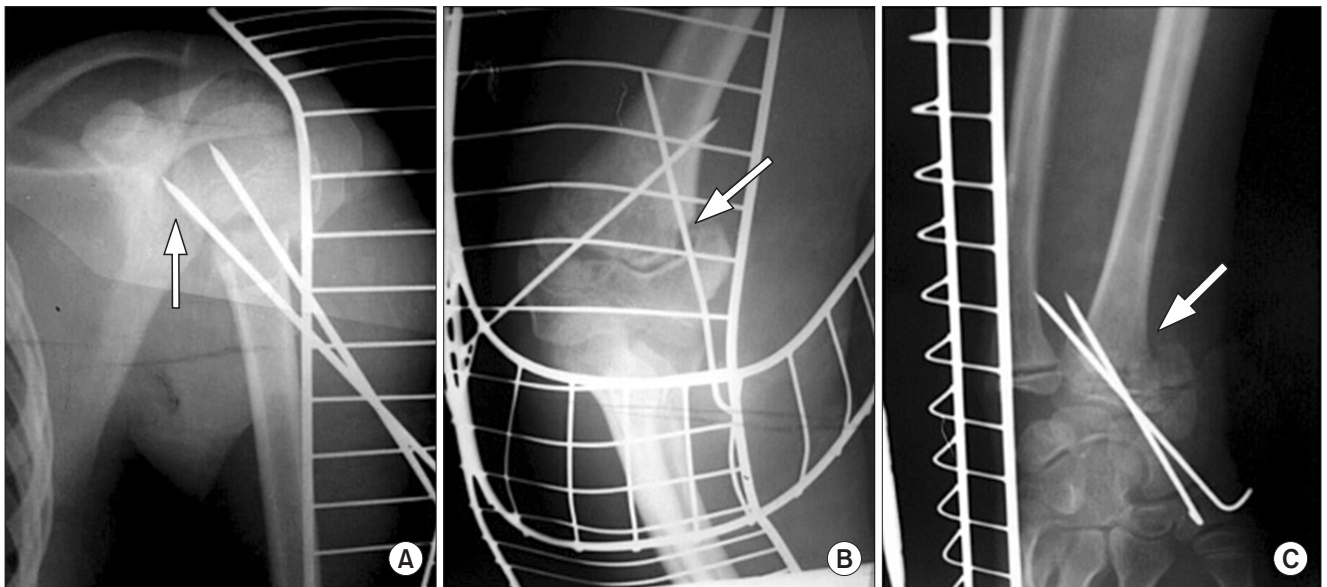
X-rays showing reunion of the limb at 6 weeks after surgery in the ipsilateral humeral (A), supracondylar (B), and distal radial limb (C). Each arrow indicates the point of injury.
